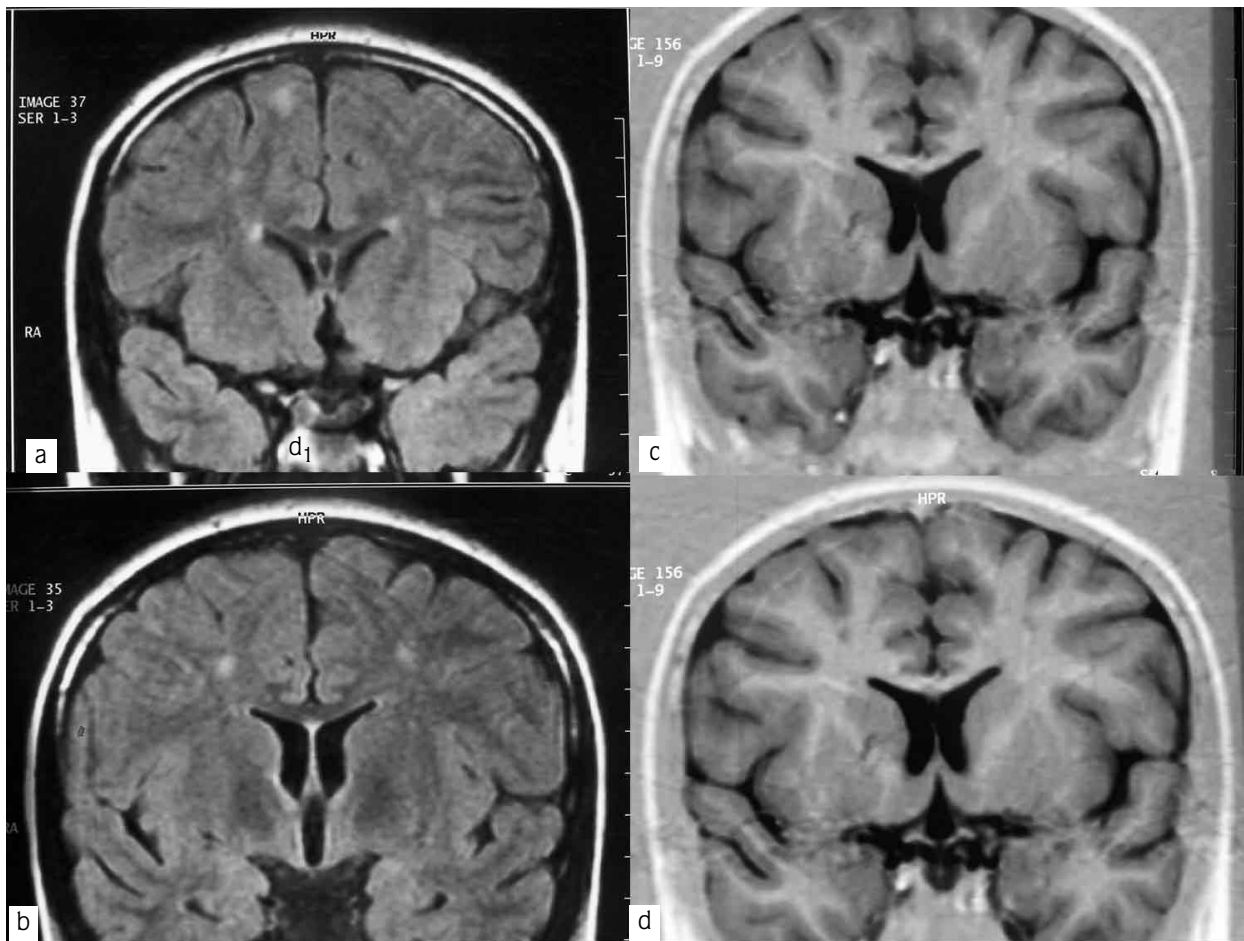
Multiple infarct areas are seen in the frontal and parietal subcortical white matter on coronal Flair (a,b) and T1w (c,d) MRI.
